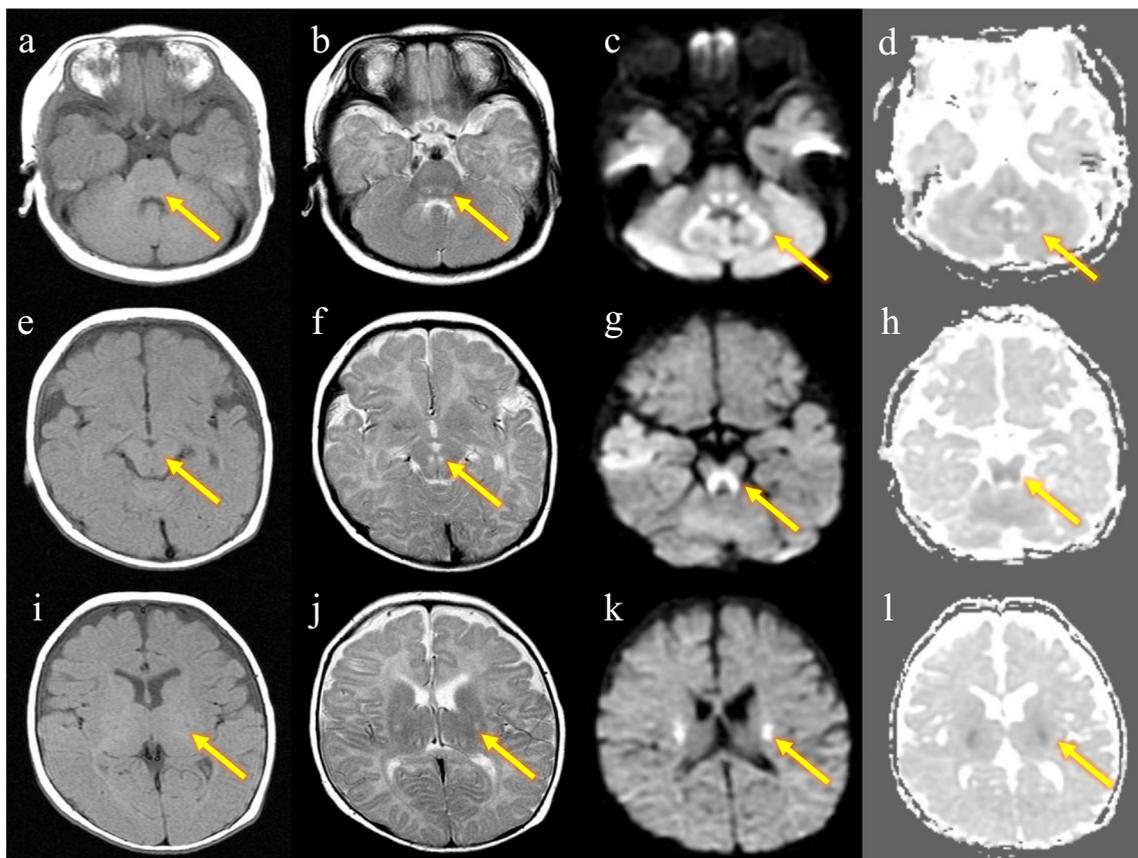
Brain MRI of the patient at the age of 3 months. Hypointensities on axial T1-weighted images (a, e, i), hyperintensities on axial T2-weighted images (b, f, j), DWI (c, g, k), and corresponding low signals in axial ADC maps (d, h, i). Abnormal signals in the cerebellar white matter including the dentate nucleus (a–d), dorsal midbrain (e–h), and posterior limbs of the internal capsules (i–l) are shown.
